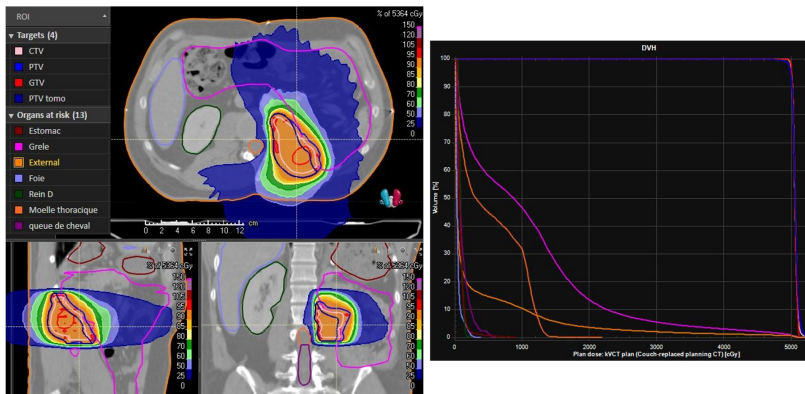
Typical interface of a TPS. Left is a visualization of the CT with the isodose lines superimposed in colors, the legend represents the ROIs. Right is the DVHs curves for each of the ROIs: the targets appear as steep lines at the right of the graph (homogeneous doses), whereas the OARs show smoother curves with various dose levels depending on the sparing reached for this specific plan (RayStation, RaySearch Laboratories).
